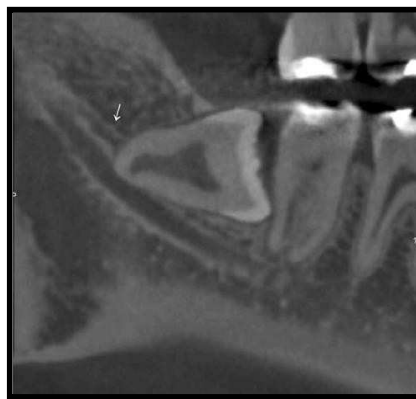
CBCT image shows canal type 2 (dental canal type)
